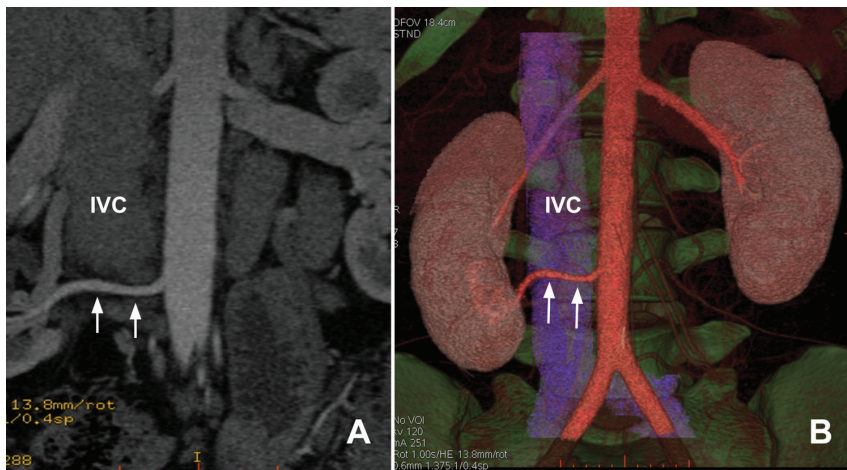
23-year-old female donor with precaval right renal artery. A) 3-D maximum-intensity-projection (MIP) CTA image and B) 3-D volume-rendered CTA image demonstrate two right renal arteries. Lower right renal artery locates anterior to IVC (white arrows in A and B)
